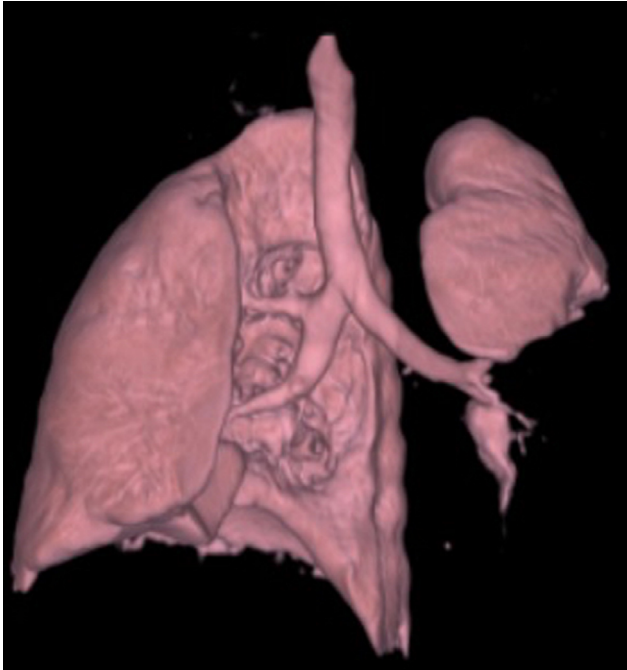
Chest CT reconstruction of the lung, remarkable for the left lower lobe collapse.
